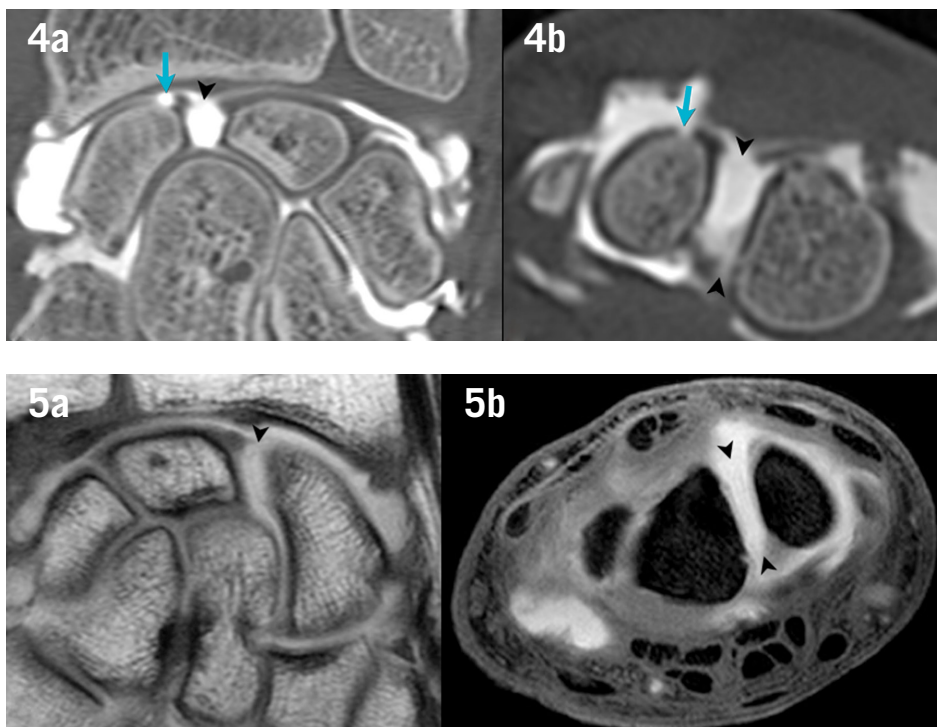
CT-arthrography in coronal and axial planes show complete tear of the SL (arrowheads) and chondral defect of the proximal scaphoid (blue arrows).
